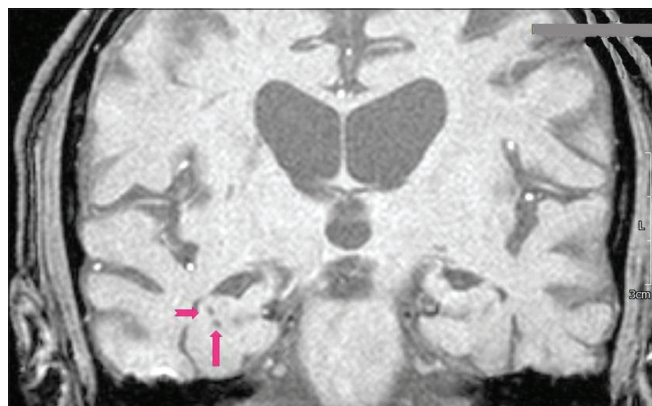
A high-resolution coronal T1-weighted image at the level of the hippocampus. HCs (long arrows) are defined as sharply demarcated cystic structures (iso-intense with CSF) localized at the apex of the hippocampal fold
